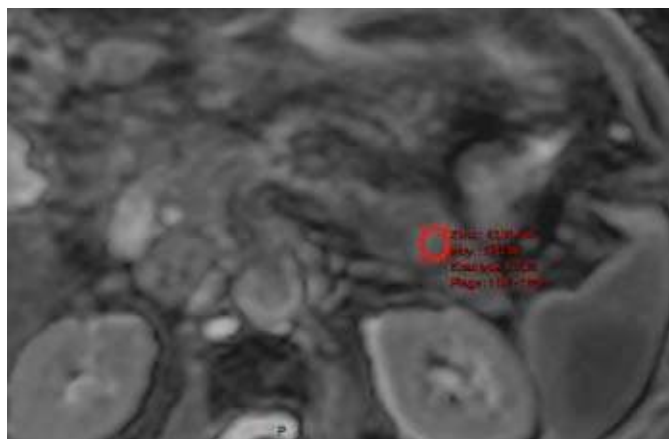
Benign G1 pNET. A. Transverse T1-weighted pre-contrast MRI, showing a hypointense rounded well-delineated tumor in the tail of the pancreas.. B. Transverse T1-weighted i.v. gadolinium contrast-enhanced MRI in the arterial phase, showing a slight peripheral contrast-enhancement of the tumor (arrow). C. DW MRI, b 800 showing the pNET slightly hyperintense (arrow). D. DW MRI, apparent diffusion coefficient (ADC) map, showing an intermediate ADC value of 1,54, in favor of a benign lesion.
